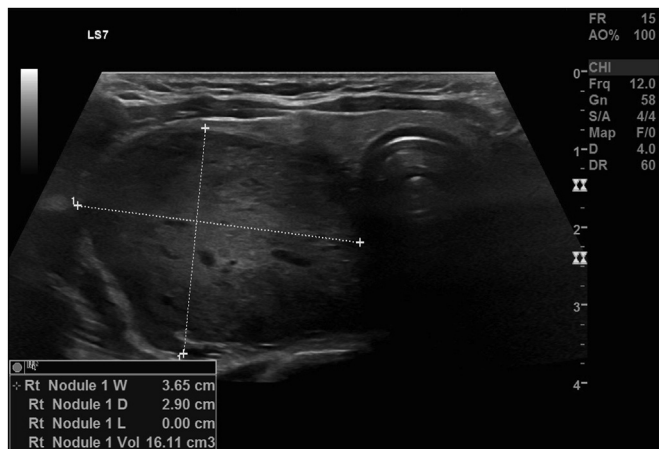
Axial view of preoperative paraganglioma on ultrasound.
